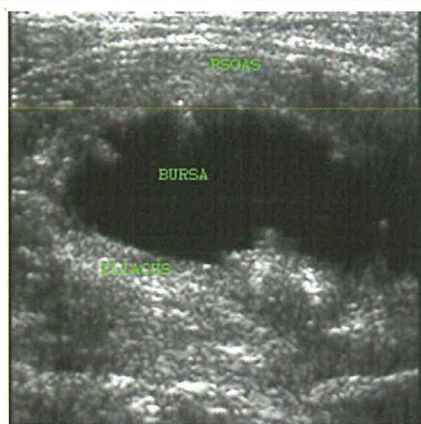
Iliopsoas bursitis shown by ultrasound on transverse section just below the inguinal ligament in a football player following forceful flexion against resistance.
